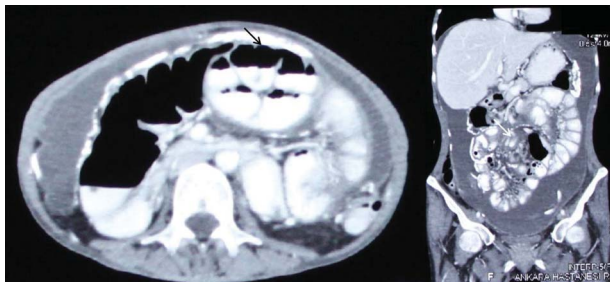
CT scan of lower abdomen shows clustered gas-containing small-bowel loops with thick membrane-like sac (white arrow) and dilated proximal small bowel with air–fluid levels (black arrow) due to intestinal obstruction.
